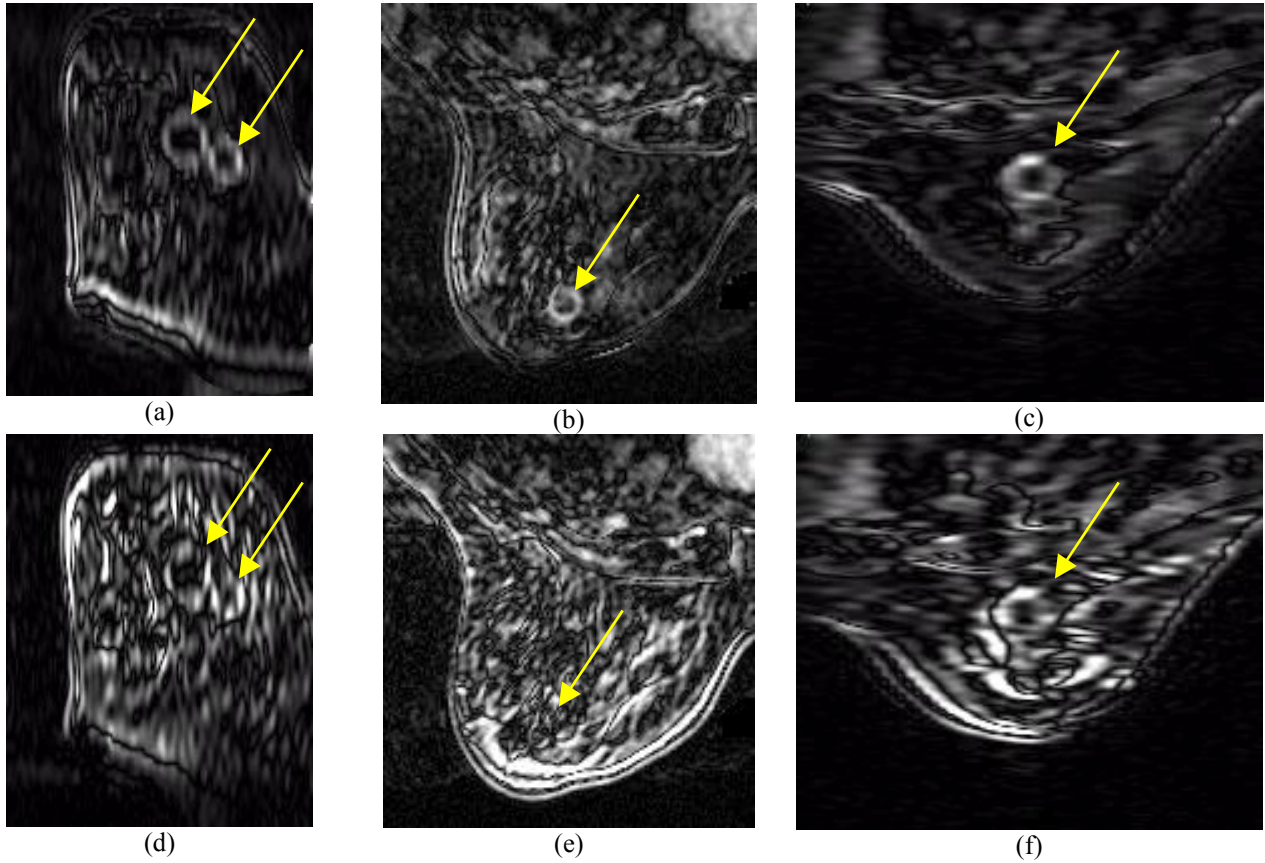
MRI differential dynamic image series (preGd-Gd1) using gradient echo (GRE) sequence. (a) coronal; (b) transaxial, (c) sagittal views of the left breast after SSHT FEM image registration and warping. (d) coronal; (e) transaxial; (f) sagittal views of left breast before SSHT FEM registration and warping. Note that the lesions are invisible or difficult to discern before SSHT FEM registration. Arrows indicate the lesions locations.
